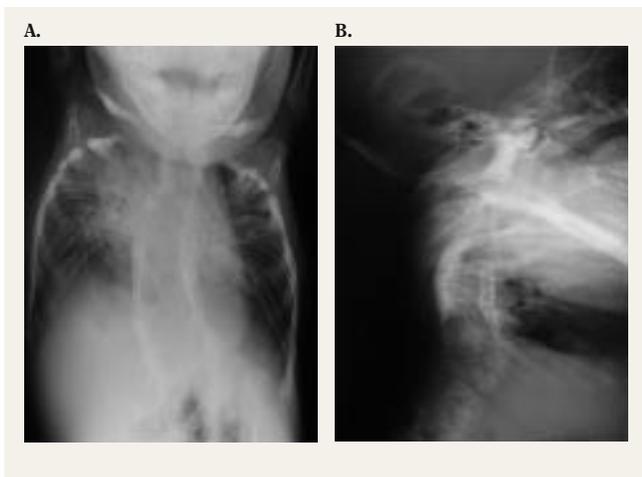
AP and lateral chest radiograph of patient with Jarcho-Levin syndrome at 2 months of age shows crab-like chest appearance and limited bilateral lung aeration and multiple rib and vertebral body abnormalities.
